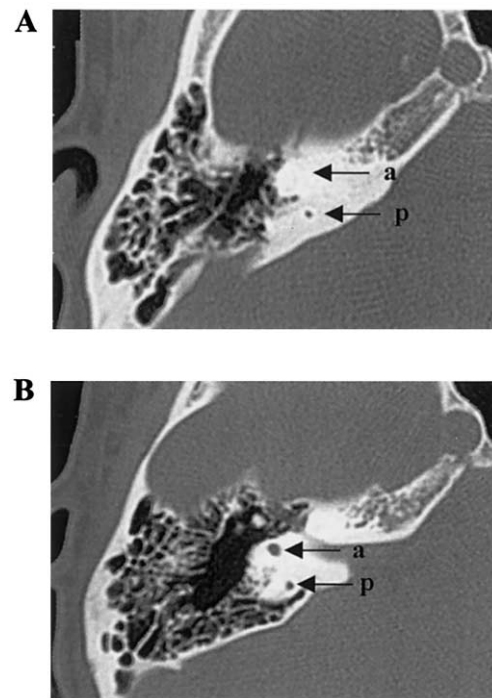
A, Axial CT scan of patient III-6, showing aplasia of the anterior semicircular canal (a) and hypoplasia of the posterior semicircular canal (p). B, Comparison with an unaffected individual.
